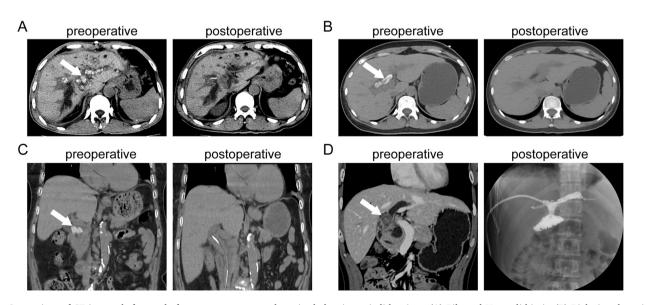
Comparison of CT images before and after percutaneous transhepatic cholangioscopic lithotripsy. (A) Bilateral Hepatolithiasis, (B) Right intrahepatic bile duct stones, (C) Choledocholithiasis, (D) Anastomotic calculi. White arrows indicate the location of the stones.
